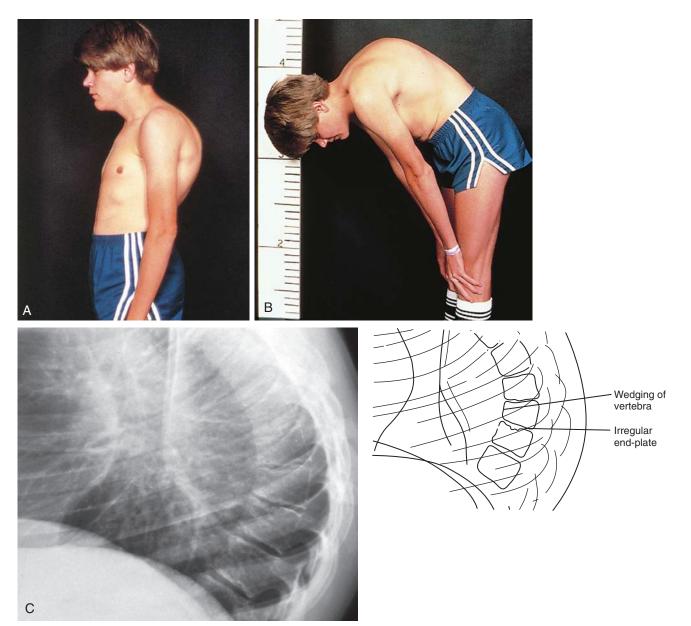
A, Severe kyphosis of the thoracic spine secondary to vertebral wedging in a patient with glycogen storage disease. To stand upright, the patient must increase his lumbar lordosis and thrust his head forward to center it above the pelvis. B, The kyphotic deformity is accentuated on forward bending. C, Radiographically, the vertebral wedging that underlies the kyphotic deformity is evident.
